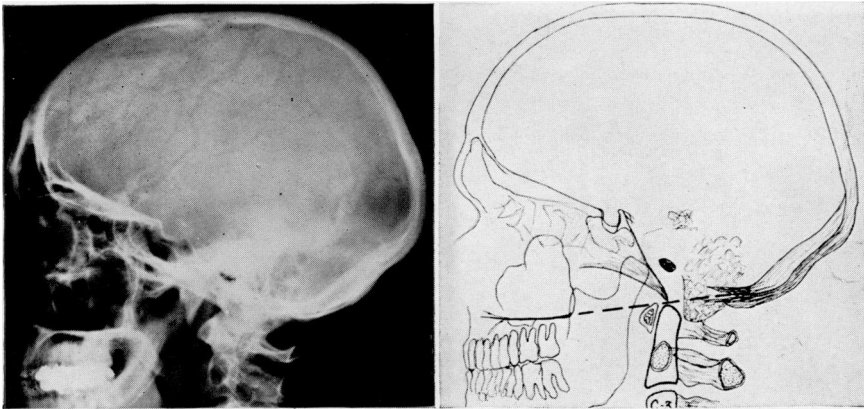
c-d. *Left:* Lateral roentgenogram of normal, for comparison. *Right:* Tracing from same. Note that all parts of atlas and axis lie caudad of the "base line."
